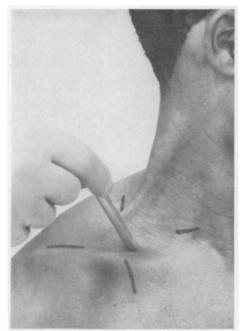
Position of Doppler probe head and skin marks.
